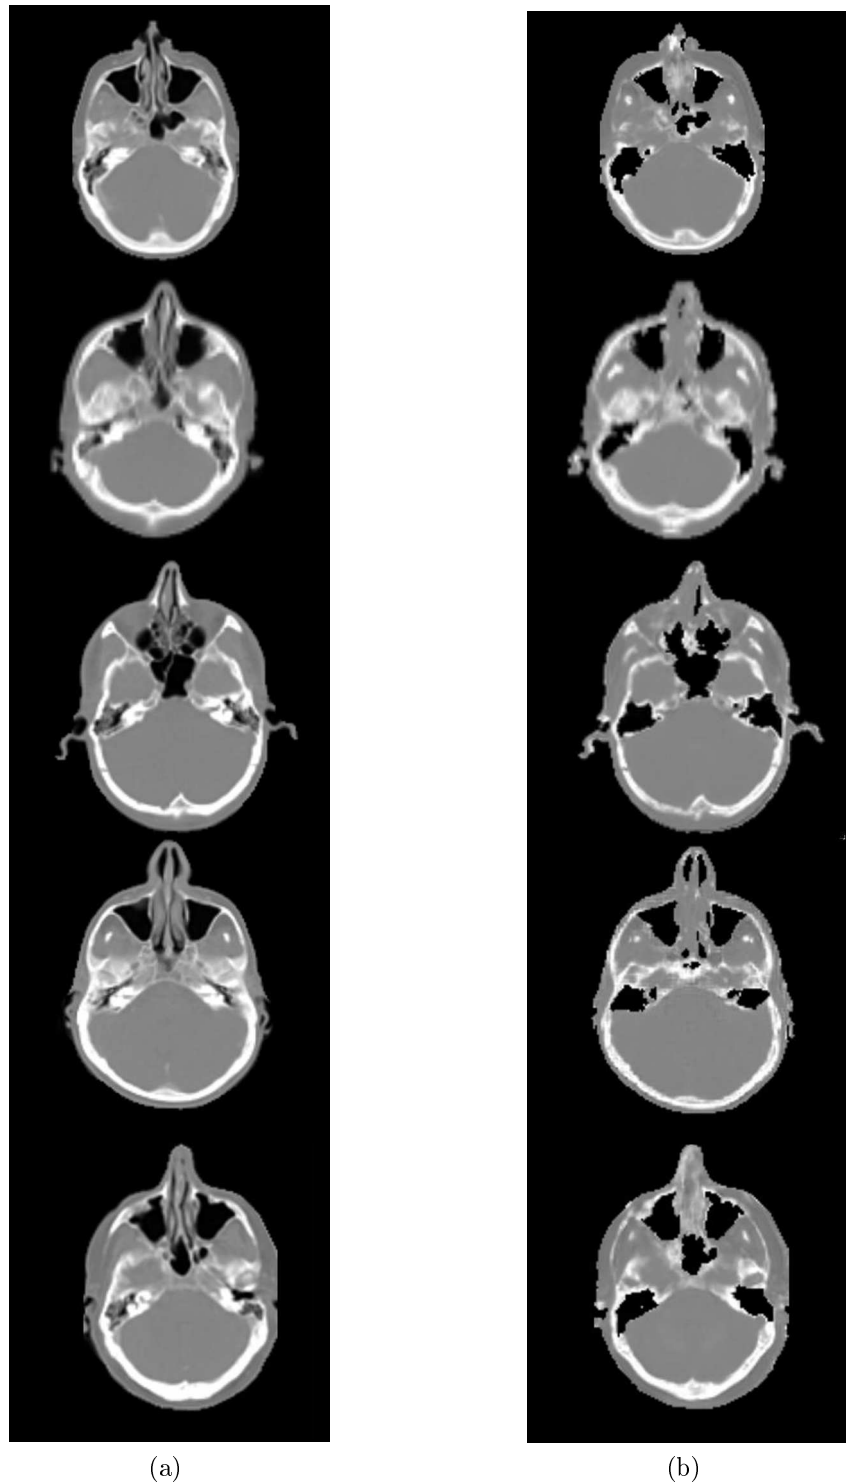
Exemplar transaxial slices from the patient CT (left column) and the corresponding slice from the generated pseudoCTs. Visually, the pseudoCTs emulate the CT, except for the air-bone mixture regions where the segmentation algorithms assign air.
